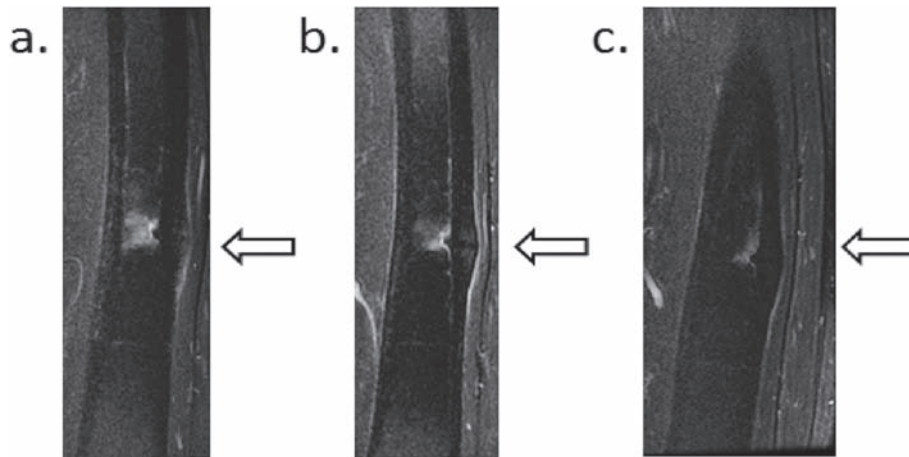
Magnetic resonance imaging scans showing change in signal intensity
